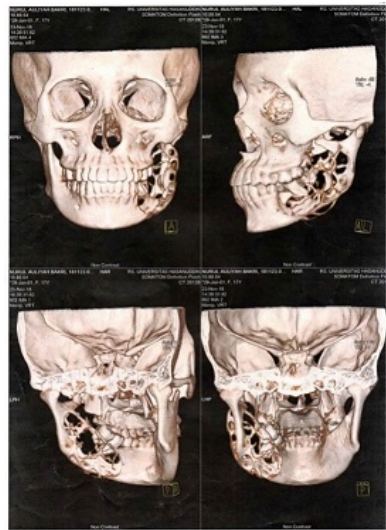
3D View of CT Scan show extension of the lesion to the buccal and lingual cortical plate
